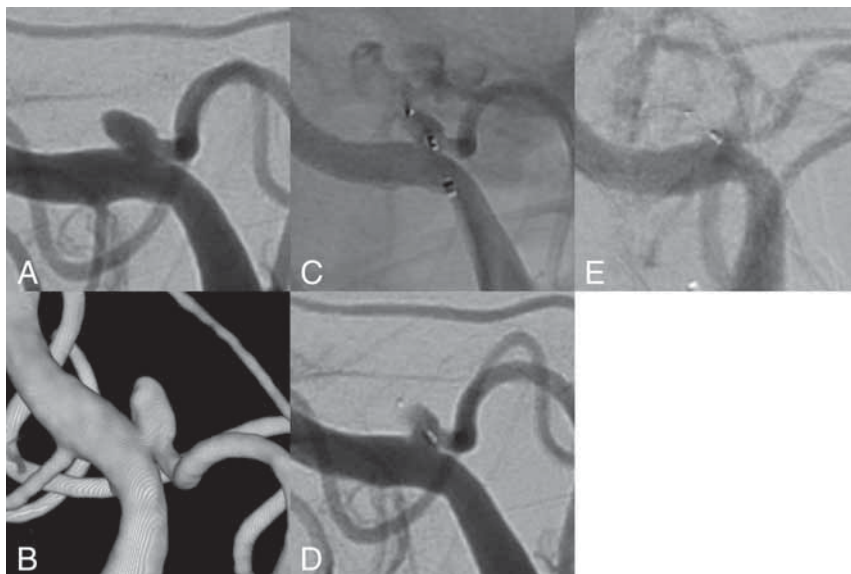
A 51-year-old female patient presented with a ruptured aneurysm at the proximal PICA (A and B). The aneurysm ruptured while the aneurysm sac was probed with the microcatheter. Extravasating contrast can be seen on the angiogram (C). However, directly after WEB deployment, the bleeding stopped due to intrasaccular stasis (D). Cerebellar infarction and herniation were excluded by a control CT (not shown). Although experiencing severe vasospasm, the patient survived and was transferred to a rehabilitation center with mild neurologic deficits (mRS 1). At 2 months, the WEB seemed to be fully thrombosed (E); however, the origin of the PICA, in particular the V4/PICA junction, appears to be dysplastic, warranting further angiographic control.
